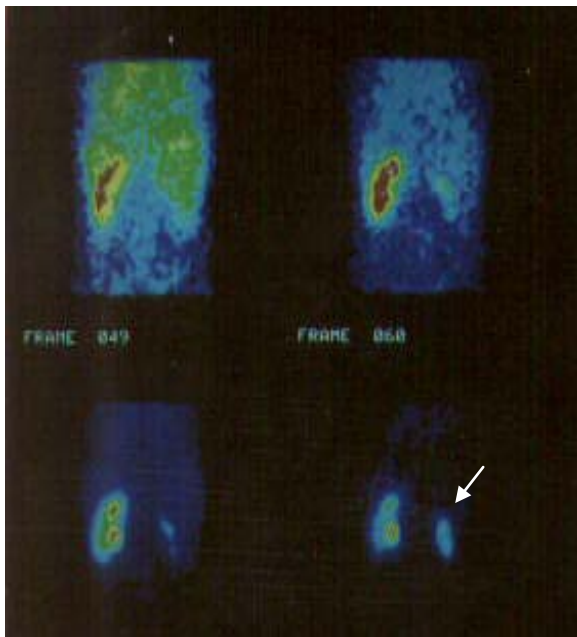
Dynamic scintigraphy of kidneys with $^{99}\text{mTc-DTPA}$. Sharp infringement of functional activity of right kidney parenchyma (arrow). Chronic pyelonephritis
